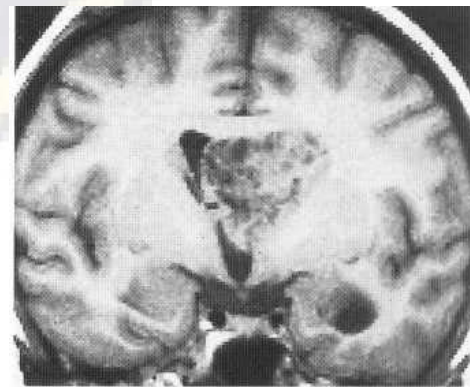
T_2 -weighted MRI study of tumour protruding into left lateral ventricle. The tumour is of mixed but mainly low signal, suggesting multilocular cysts. Ependymoma.
